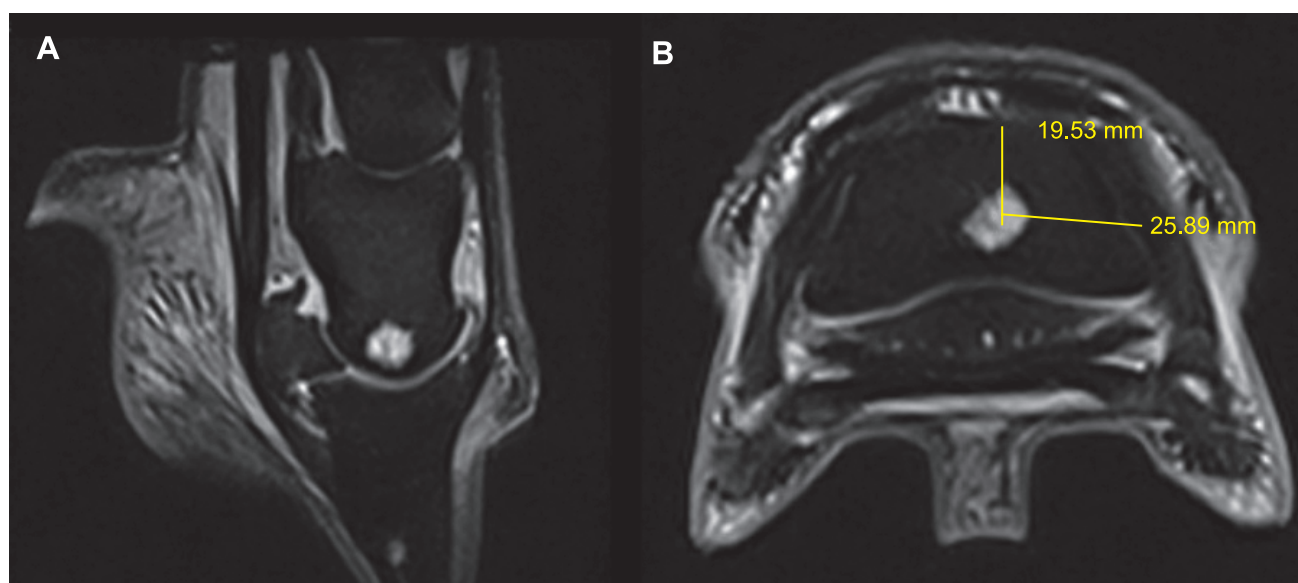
MRI visualisation of the left front distal limb in STIR projecton in sagittal (A) and transverse (B) plane presenting SBC located centrally at the distal part of short pastern bone (P2). Measurements were made prior to surgery while planning surgical approach.
